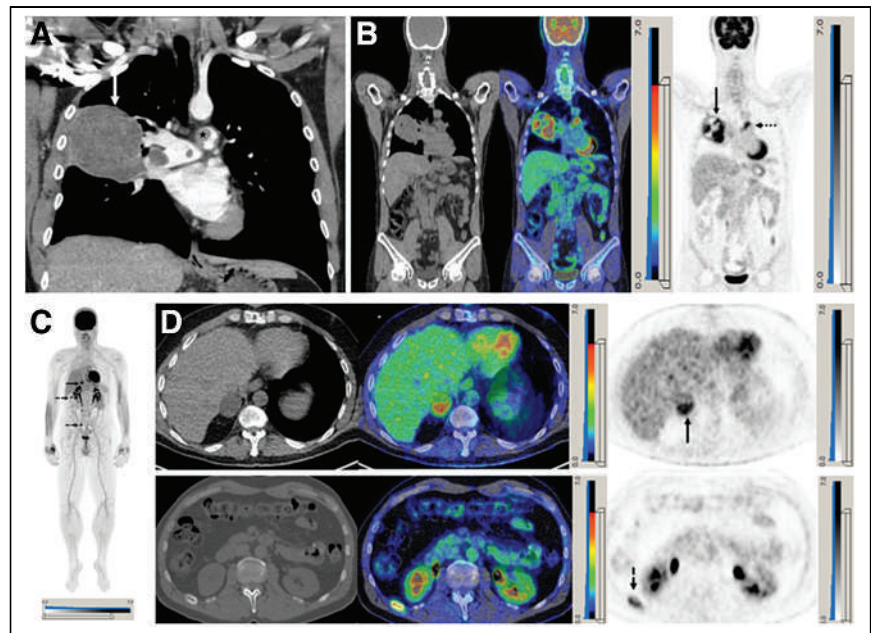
A 48-year-old man with shortness of breath. (A) Coronal contrast-enhanced CT of chest shows 8-cm right pulmonary mass invading right main pulmonary artery (arrow) and further filling defect in main pulmonary artery (star). (B) Corresponding [¹⁸F]FDG PET/CT coronal images show intensely metabolically active centrally necrotic mass invading right pulmonary artery (solid arrow) with separate tumor thrombus in main pulmonary trunk (dotted arrow). At surgery, 11.5-cm intimal sarcoma of pulmonary artery was resected. (C) [¹⁸F]FDG PET maximum-intensity-projection image performed 21 mo after surgery because of development of right adrenal nodule on CT (not shown) confirms right adrenal metastasis (solid arrow) and identifies metabolically active right rib 11 and right sacral lesions, consistent with bone metastases (dashed arrows). (D) Corresponding axial [¹⁸F]FDG PET/CT images (left, CT; middle, fused PET/CT; right, PET) showing right adrenal deposit (solid arrow) and metabolically active, expansile lytic lesion in right rib 11 (dashed arrow).
